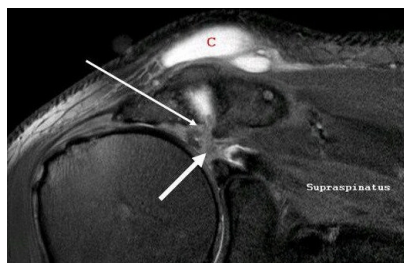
Magnetic resonance imaging shows acromioclavicular joint cyst, retracted full-thickness tear of supraspinatus muscle (thick arrow), and communication between glenohumeral joint and acromioclavicular joint (thin arrow).
